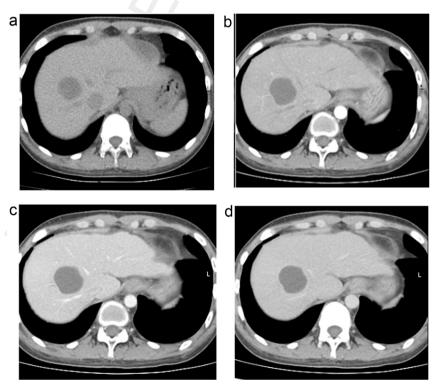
Abdominal CT showed a round hypodense area with well-defined boundary in the right lobe of the liver (A). After administering intravenous contrast media, the boundary of the lesion was mild enhancement and the lesion was more apparent (B-D).
